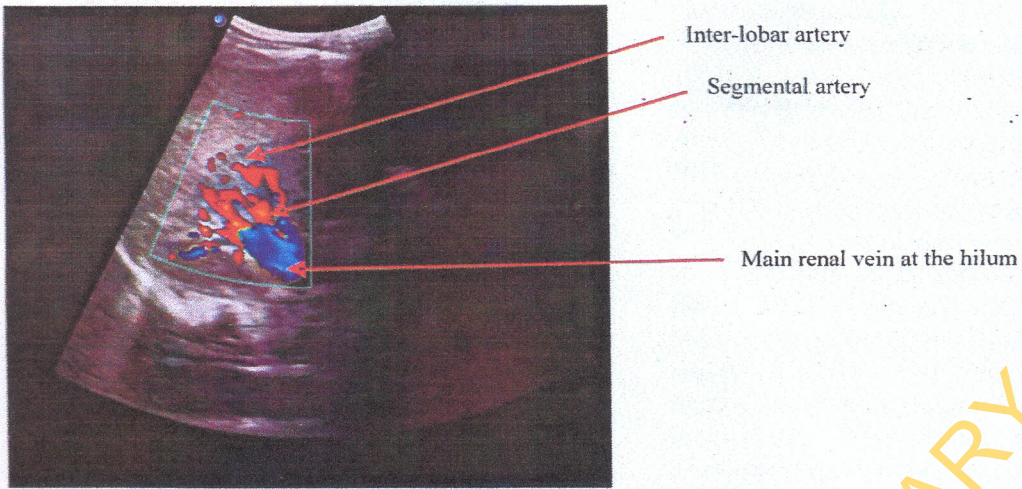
Doppler US showing color flow in the intra-renal branches of the renal artery.
